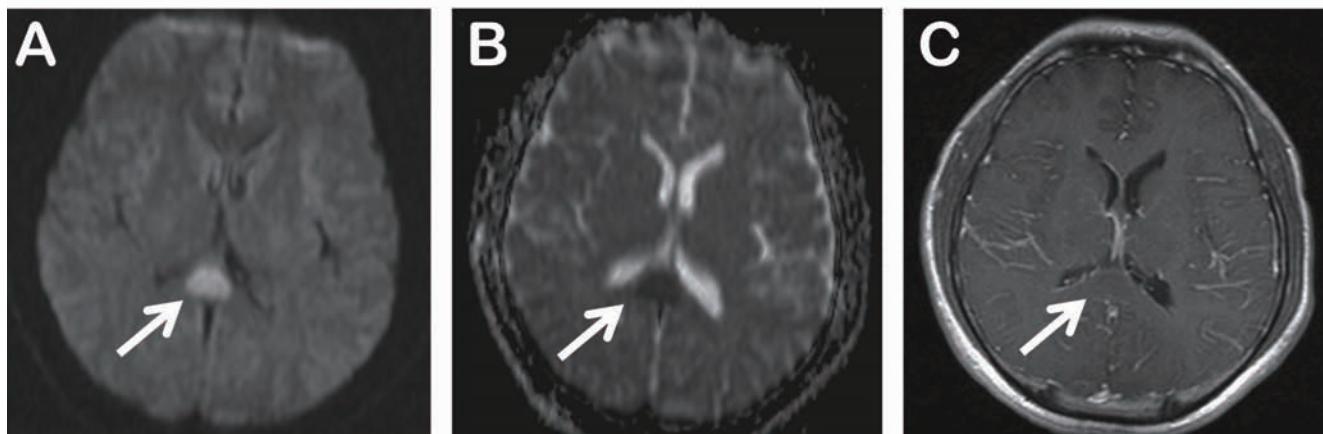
Head MRI images of the patient. Axial view of diffusion weighted image (DWI) (left), apparent diffusion coefficient (ADC) (middle) and T1-weighted images with contrast (right).
